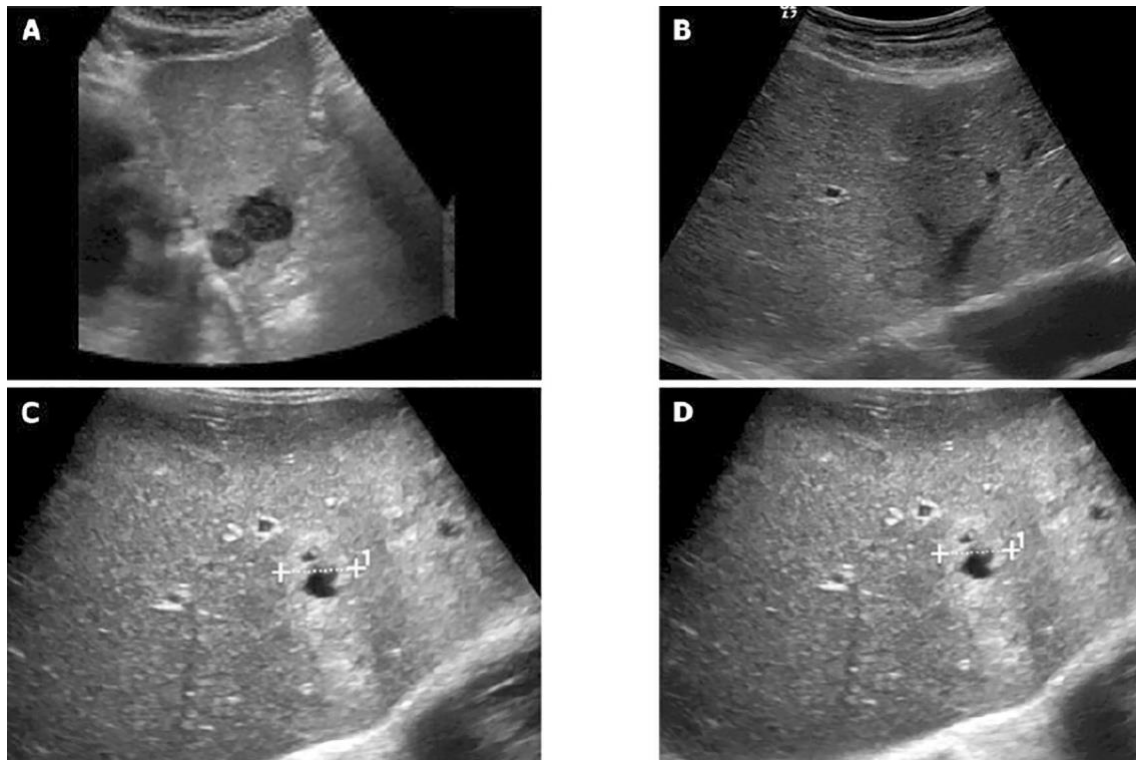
Ultrasound pictures showing the varying levels of brightness in liver metastases.
